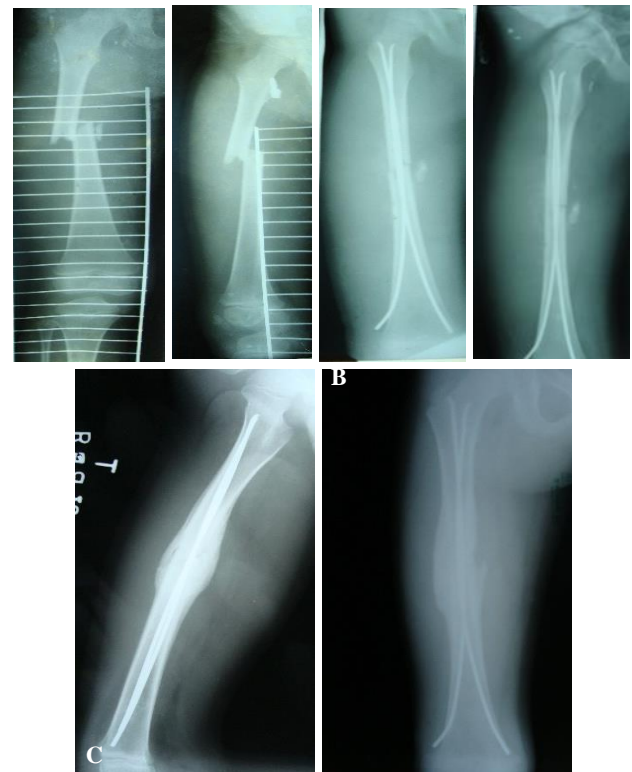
(A) Fracture of the femur; (B) postoperative radiograph of the nailed femur; (C) radiograph at 6 months; (D) radiograph after correction with a dynamic compression plate.
